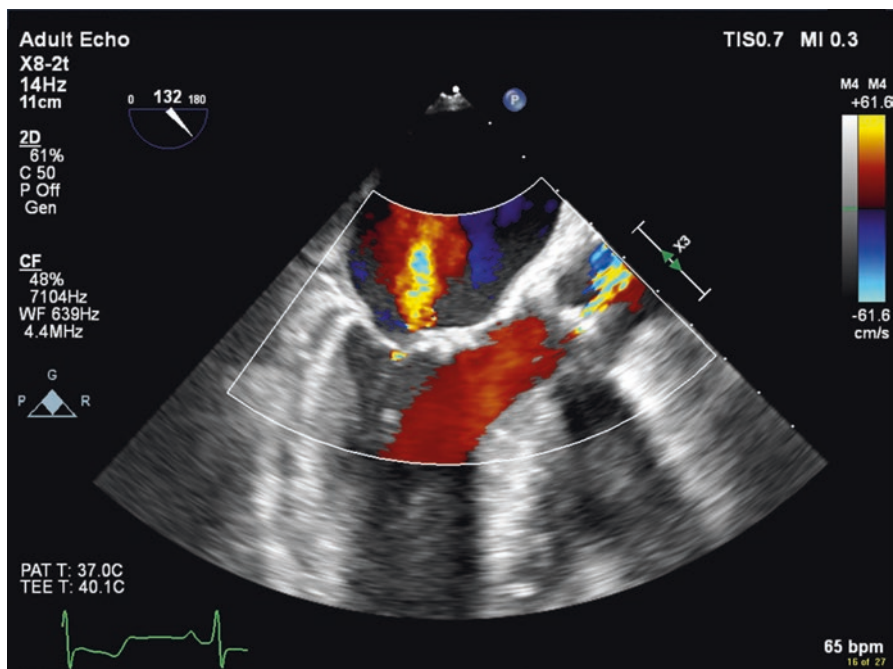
Color Flow Doppler. The Nyquist limit scale can be seen at the top right corner of the image. By convention, blue color represents blood flow away from the probe while red signifies flow toward from the probe (BART = Blue Away, Red Toward). Note in this image that blood in the LVOT is red because it is flowing toward the probe. Similarly, flow in the aortic root has blue mixed in, signifying turbulent flow and aliasing. In this patient, the aortic valve is stenotic and the velocity through the valve exceeded the Nyquist limit, resulting in aliasing
